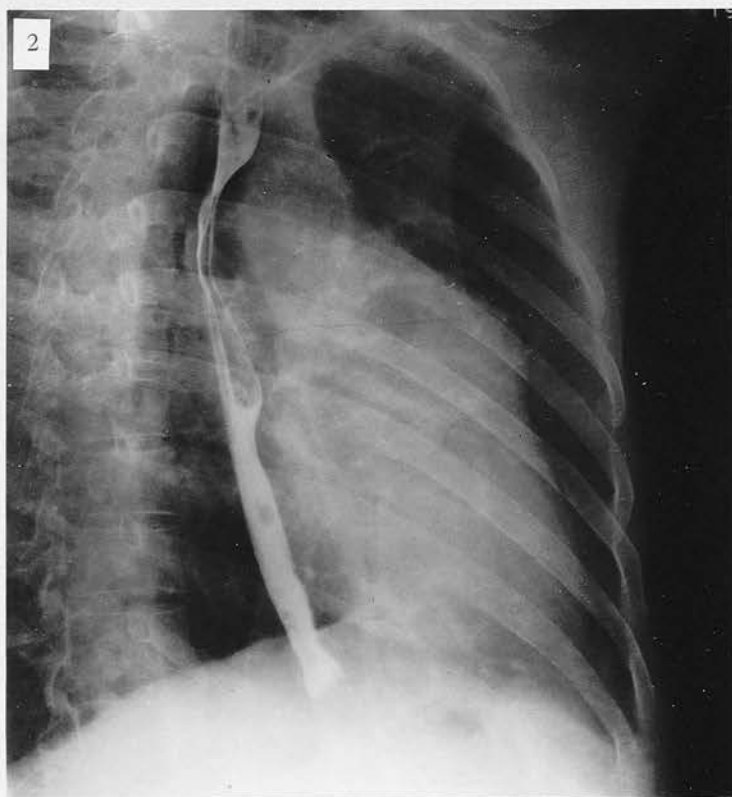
Radiograph of Case 77. Unusual appearance of Pulmonary Artery in adult.
